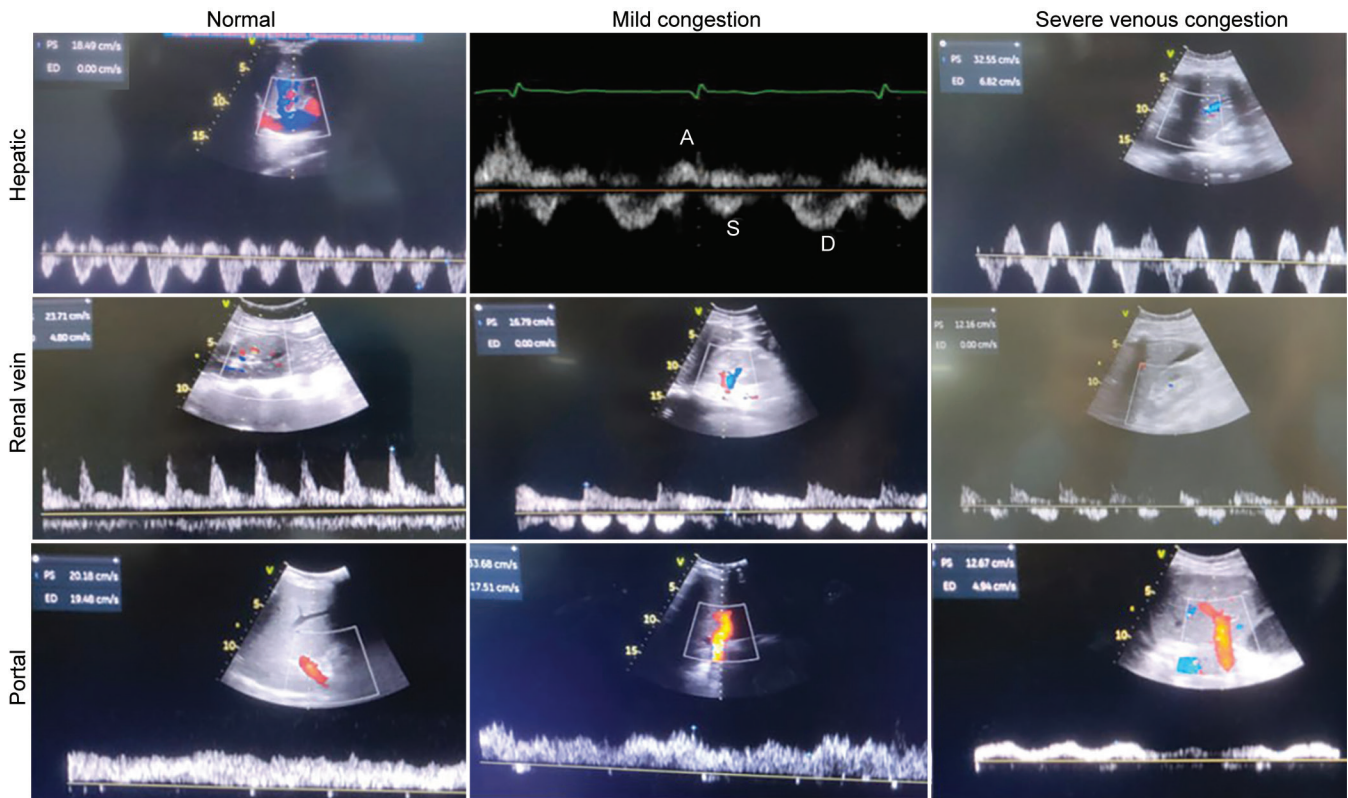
Doppler ultrasound images demonstrating venous congestion patterns in hepatic, portal, and renal veins used for VExUS scoring in critically ill patients
